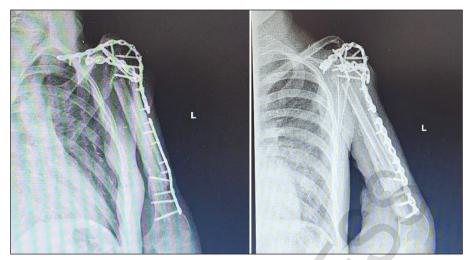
Postoperative follow-up X-ray images of the patient after 2 years.
